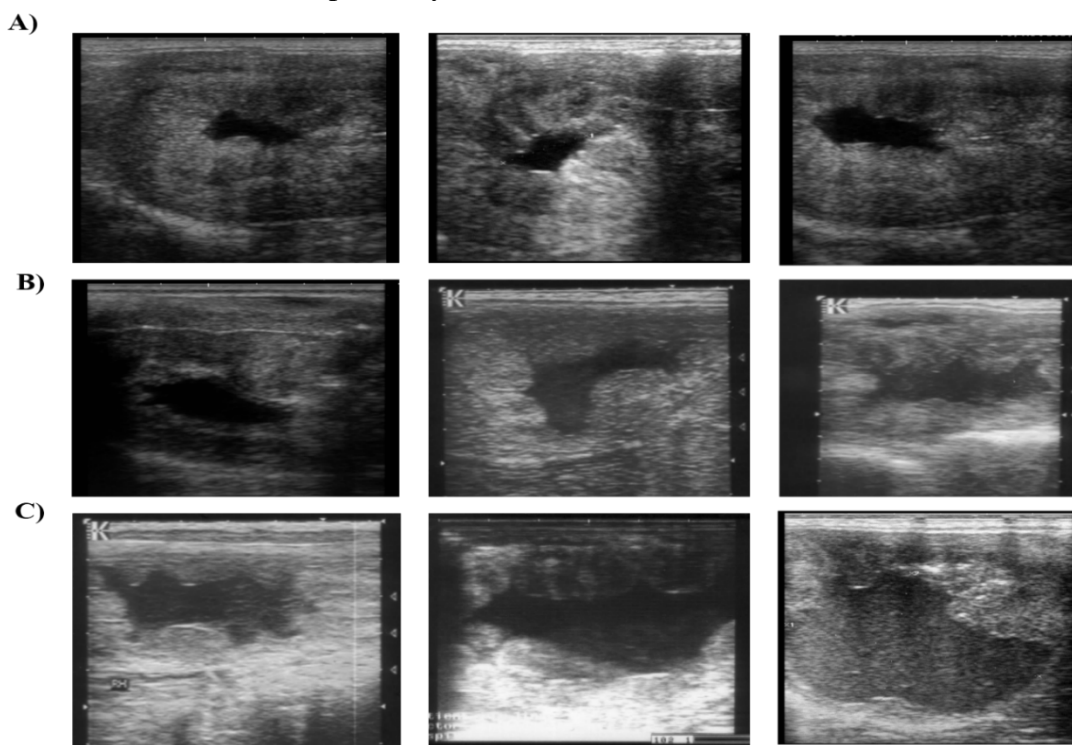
Ultrasonographic characteristics of mare’s uterus with different degrees of endometritis. A) Slight amount of anechoic fluid (black). B) Moderate amount of hypoechoic fluid (gray). C) Large or severe amount of hyperechoic fluid (black with white particles)
